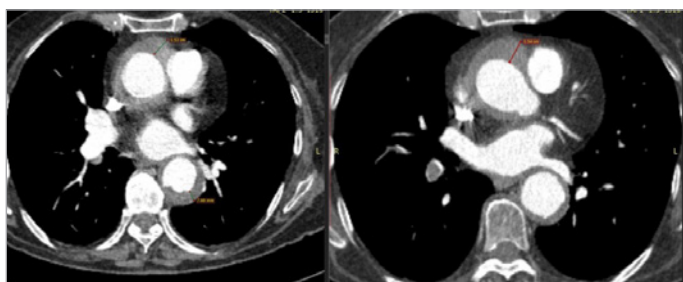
CT scan revealing aortitis.
